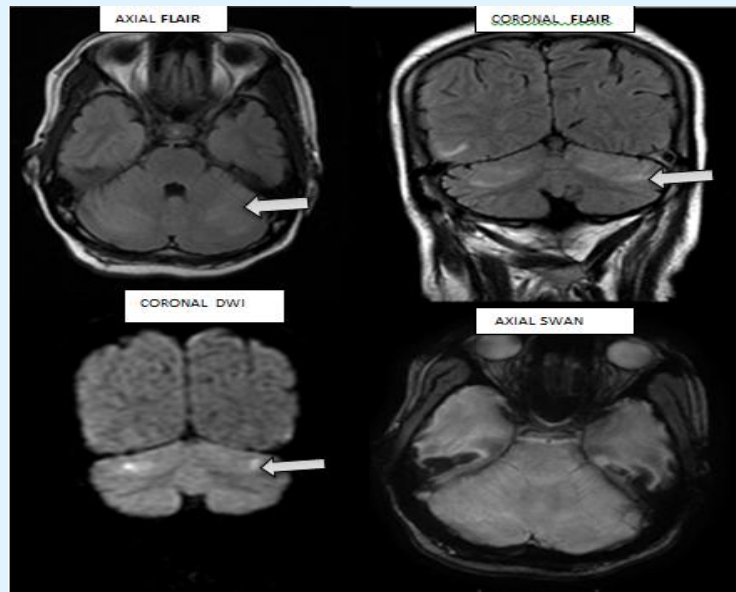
20 year old postpartum female with antepartum pre-eclampsia now co seizure. Axial and Coronal T2 FLAIR, DWI and SWAN reveal high signal intensity involving bilateral cerebellar hemisphere with diffusion restriction-Indicative of PRES.
